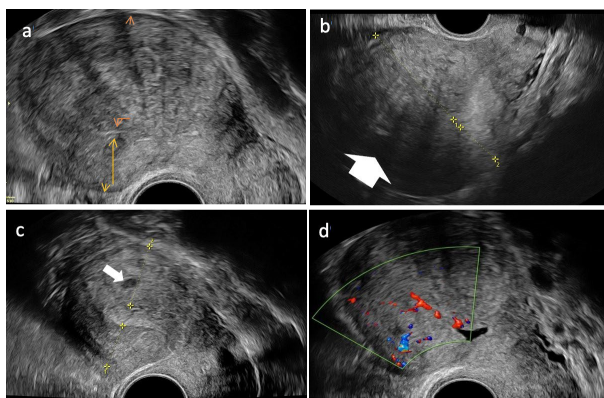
2-D sonographic imaging of a non-gravid uterus in a longitudinal section highlighting typical phenotypes of adenomyosis. (a) See the globular shape with an asymmetrical myometrial wall-thickening (posterior thicker than anterior – orange arrows), the heterogeneous myometrium with hyperechoic regions, and hypoechoic striations. (b) asymmetrical myometrial wall-thickening (anterior thicker than posterior), the heterogeneous myometrium with fan-shaped shadowing (white arrow). Note the ill-indistinct endometrial-myometrial border (c) A solitary myometrial cyst on the posterior wall (white arrow). (d) Few diffuse vessels (increased vascularity) can be seen on colour Doppler
